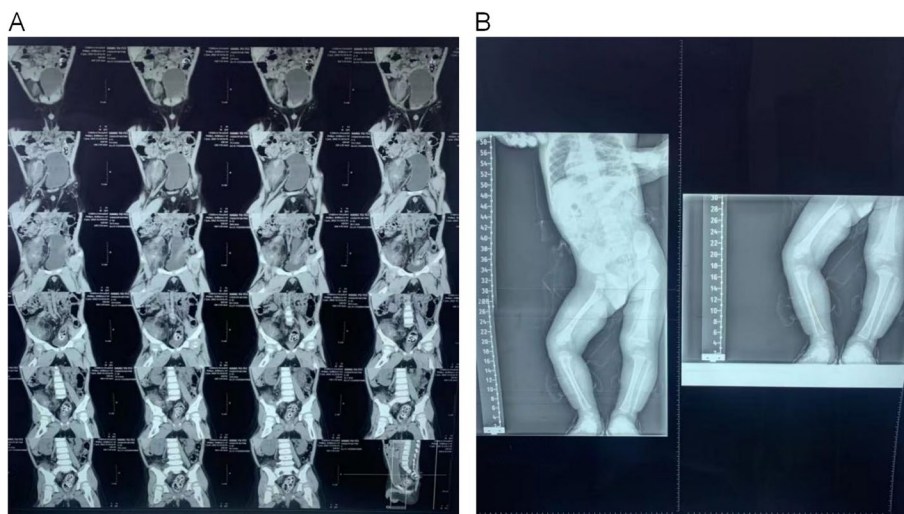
CT examination and X-ray. A Abdominal CT: right iliopsoas muscle mass, size about 79 * 62 * 40 mm. B Long bone X-ray: the right femur, tibia, and fibula are thinner than the opposite side, and the right lower limb is bent and rotated
